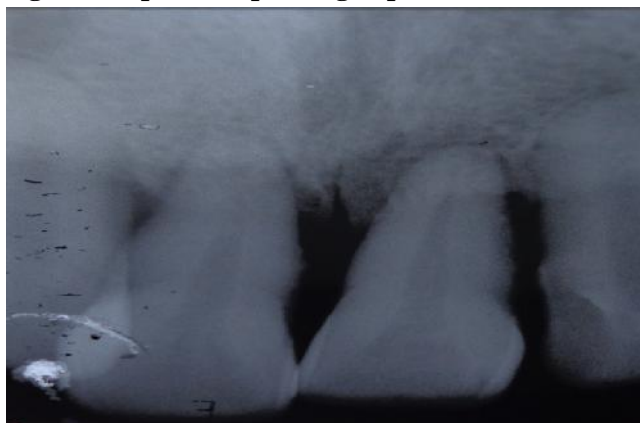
Radiographic interpretation showing extruded 21 with poor bone support.
